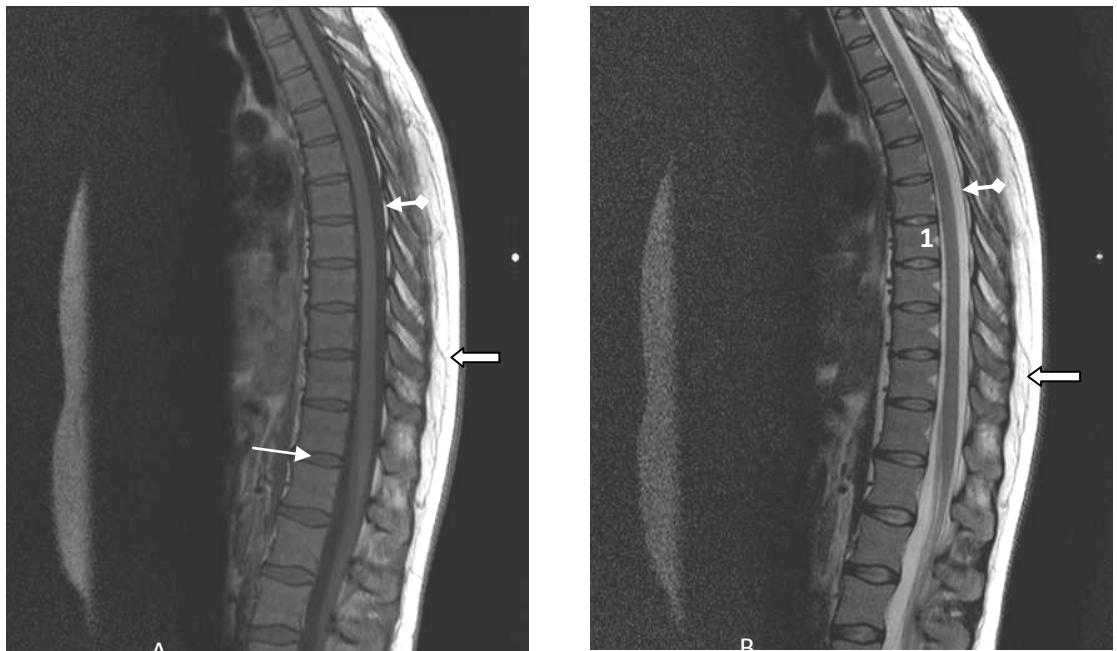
MRI. T1-WI (A) and T2-WI (B) of the thoracic spine in the sagittal projection. Visible vertebral bodies correct form (1), intervertebral discs without changes (arrows). In the lumen of the dural sac – the spinal cord as a dark band of uniform width. Note that the cerebrospinal fluid is white on T2 WI and dark on T1 WI (arrows with rhombus). Fat is white on T1-WI and T2-WI (curly arrows). Norm
